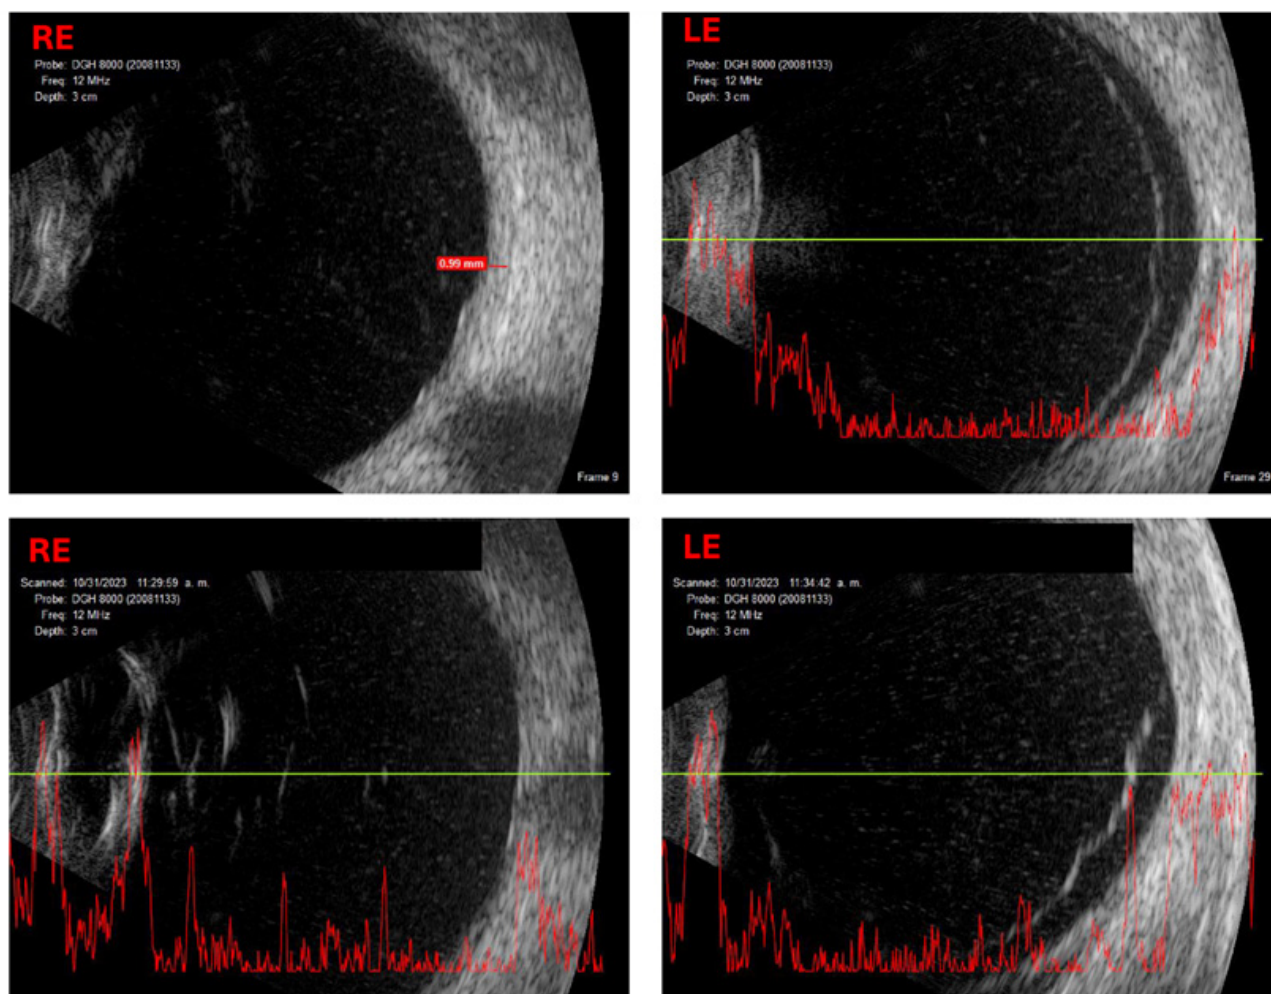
Ultrasound Scan A-B, where it is confirmed total vitreous detachment of RE and LE, as well as serous retinal detachment LE.
